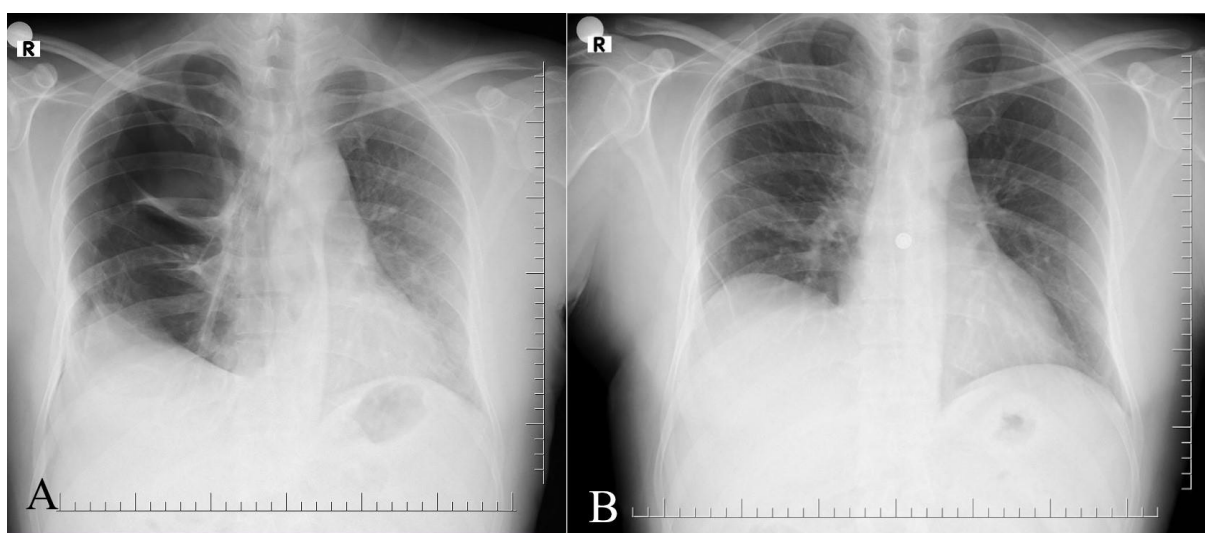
A) PA chest x-ray revealing recurrent right-sided pneumothorax and fibrothorax with an elevated right diaphragm. B) PA chest x-ray of the patient on his 10th postoperative month.
